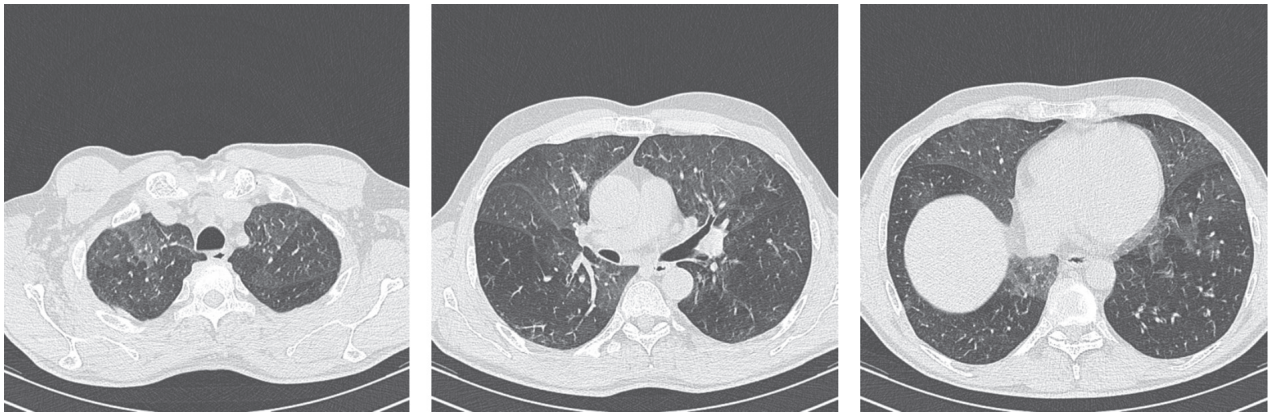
HRCT performed immediately after the second HP/EAA relapse, showing more diffuse patchy ground-glass opacities and patchy areas of mosaic perfusion, with some nodular lesions and air trapping.
